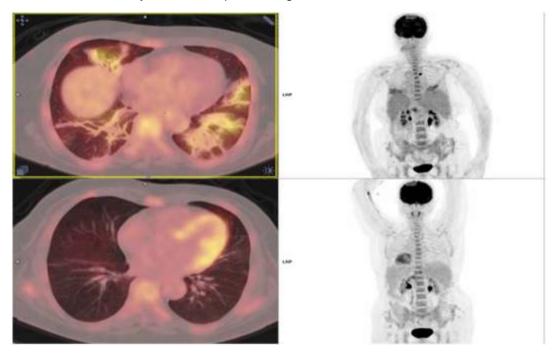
Transaxial fusion PET/CT (a, b) and maximum intensity projection (c, d) images showed post-chemotherapy collapse and consolidation (a, c) in a 77-year-old male patient diagnosed with a hematologic malignancy
